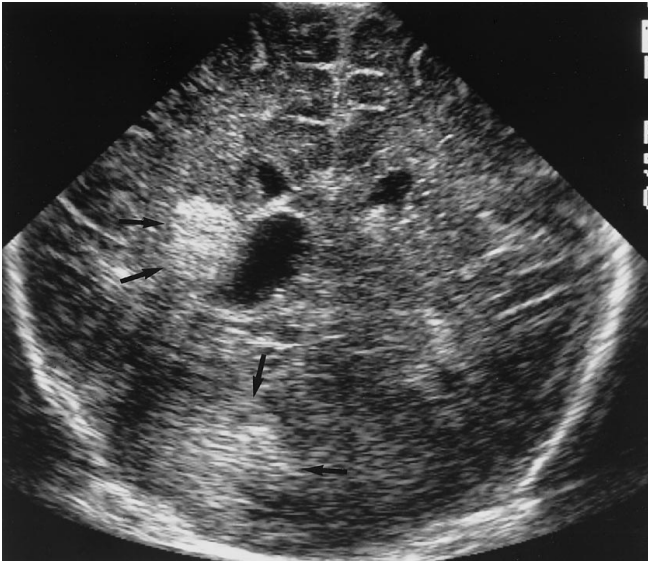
Cranial sonogram in the coronal plane reveals large echogenic lesions, consistent with hemangiomas, within the right parietal and occipital lobes (*arrows*). Similar lesions were seen throughout the cerebral hemispheres bilaterally
